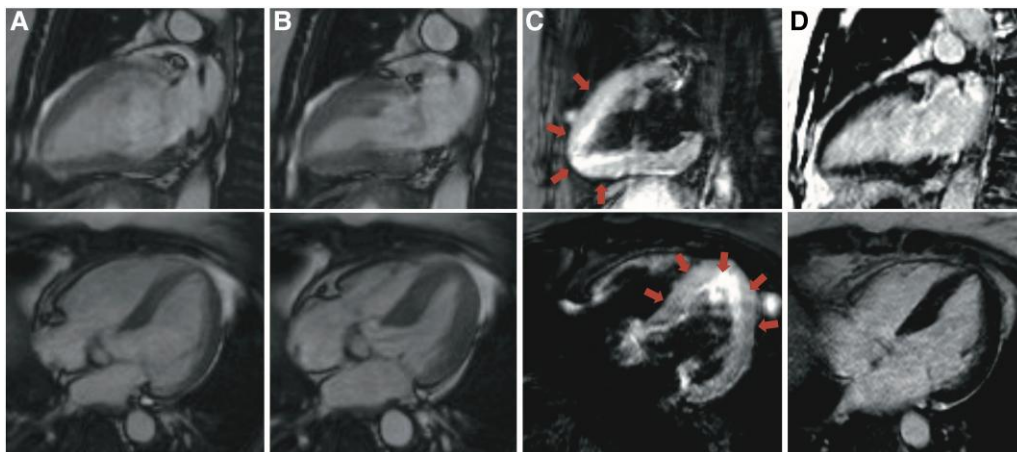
Cardiac magnetic resonance imaging showing snapshot of cine two-chamber (top row) and four-chamber views (bottom row) using steady-state free precession (SSFP) sequences timed at diastole (column A) and systole (column B). Column C shows the corresponding black blood T2-weighted spin echo triple inversion recovery (STIR) imaging with evidence of myocardial oedema of the mid to apical left ventricle (arrows) and the absence of abnormal late gadolinium enhancement on delayed T1 weighted Phase Sensitive Inversion Recovery sequences (Column D).
